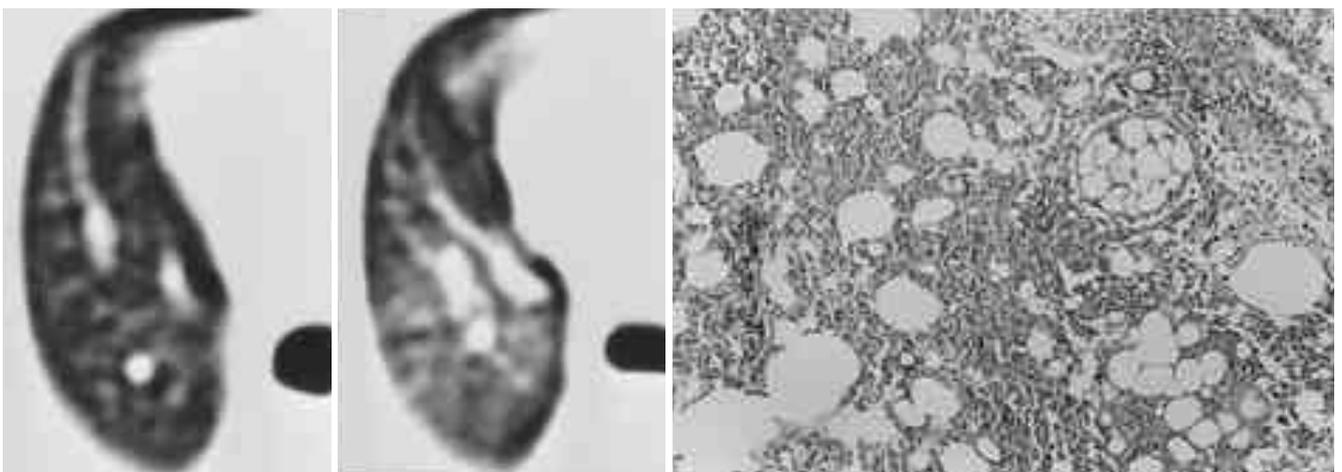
Parenchymal opacities on follow up CT scans
